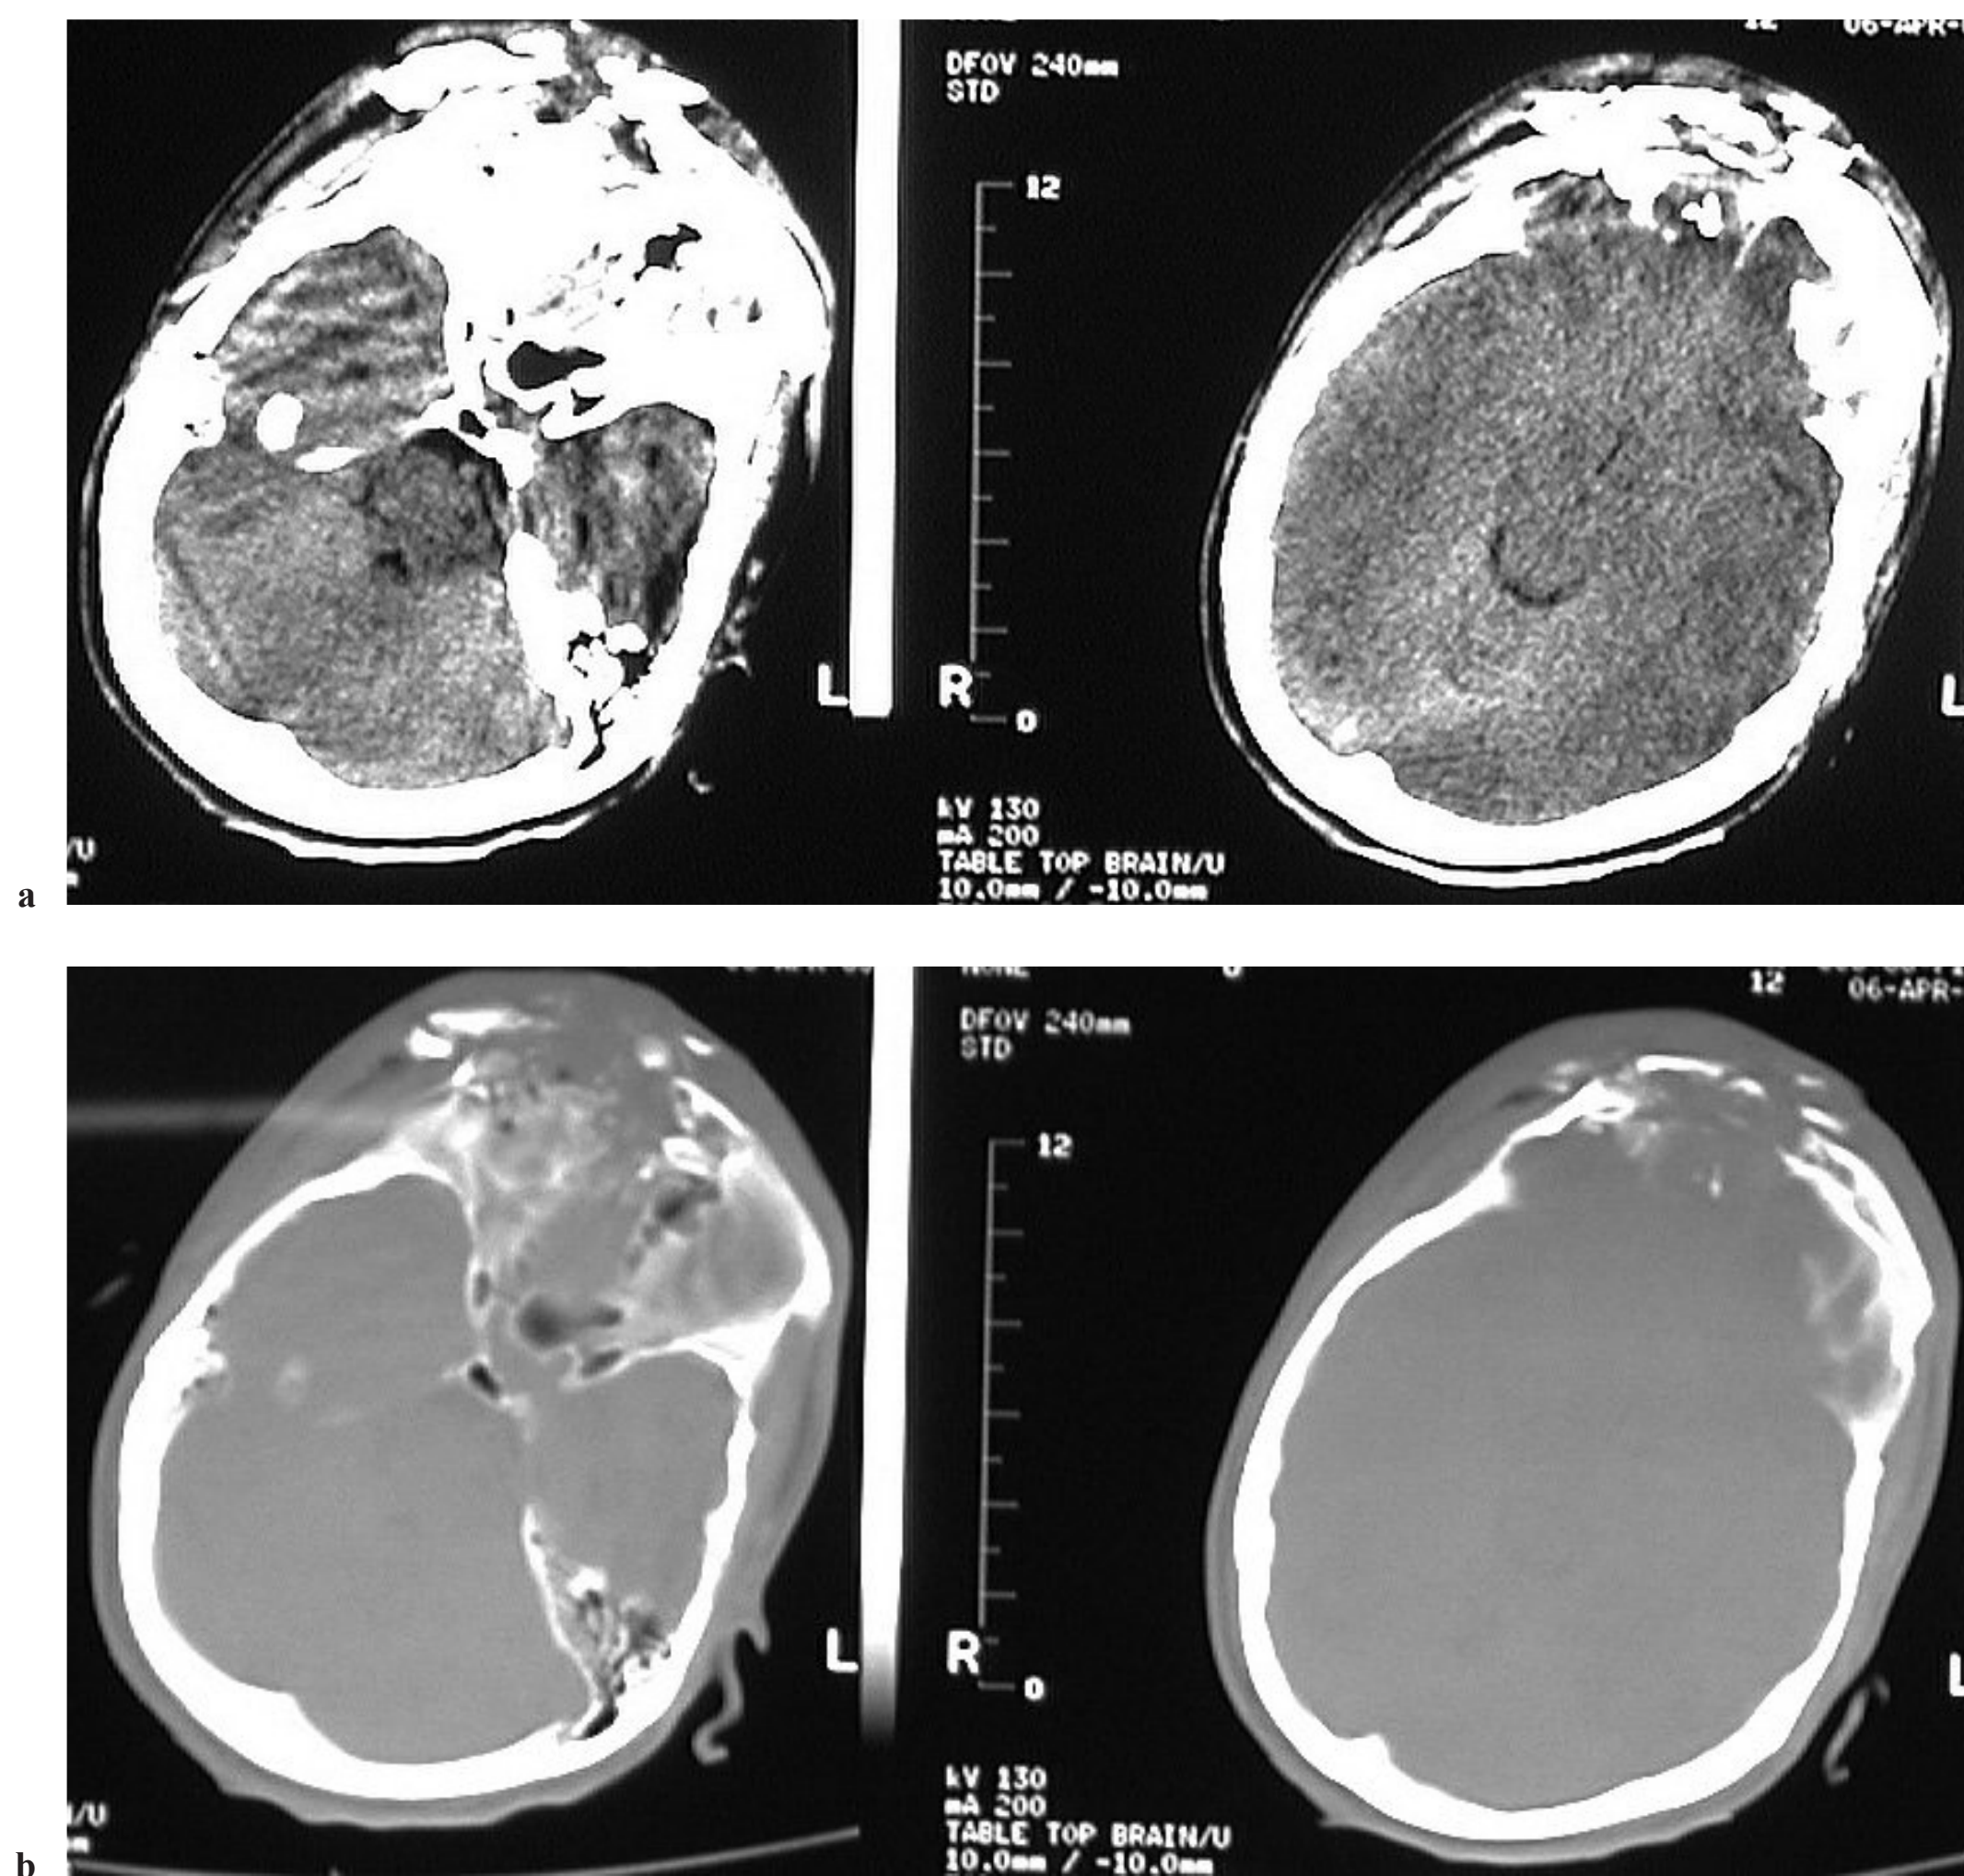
CT (a) brain and (b) bone images of a frontotemporoparietal IED injury demonstrating typical massive soft tissue swelling, air-filled sinus disruption, intracranial fragments, and epidural hematoma. These are actual hardcopy images from in-theater CT scan operating under extreme weather and force protection conditions. Digital records are not available for higher resolution.
